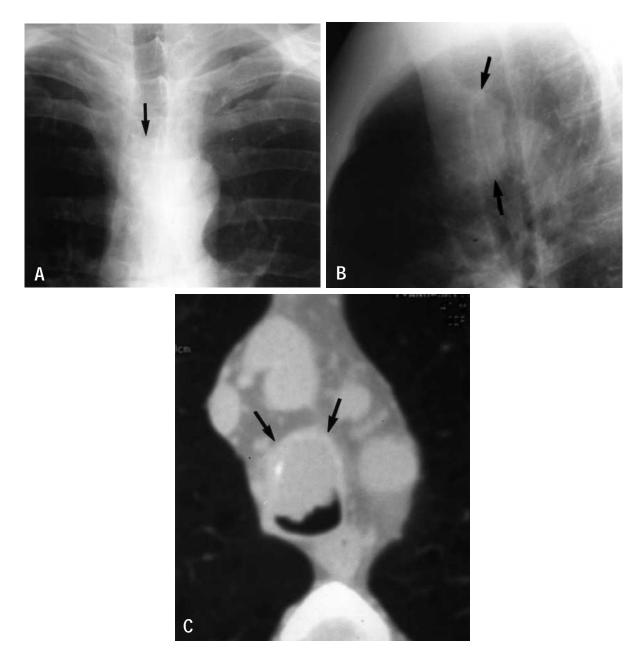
A and B, Chest radiographs demonstrate a soft tissue mass (*arrows*) within the trachea. C, CT scan of the chest shows a large soft tissue mass (*arrows*) that almost totally obliterates the tracheal lumen. There may be subtle extension outside the anterior wall.
